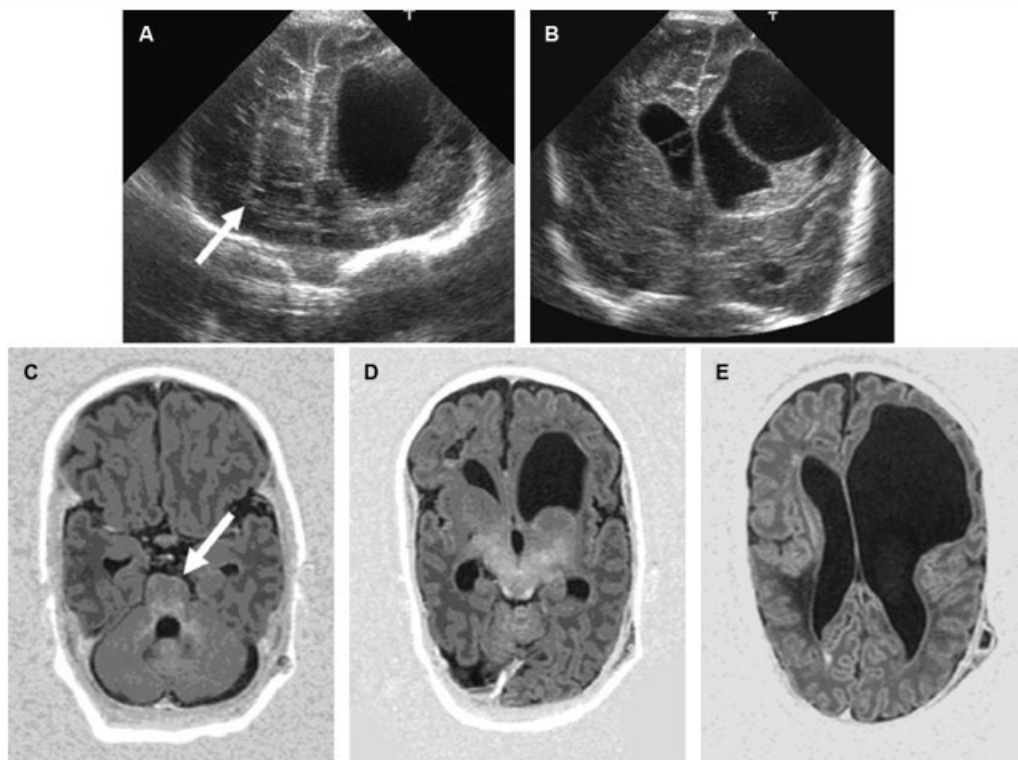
Day 5 cUS (A, B) and term-equivalent age magnetic resonance imaging (C–E) of Patient 1. The coronal ultrasound images show a small cyst in the right frontal periventricular white matter (arrow) (A), and the large left-sided PC (B) with a midline shift to the right and a resolving clot in the left lateral ventricle. The axial inversion recovery sequence images show Wallerian degeneration (arrow) (C), several periventricular cysts in the right frontal periventricular white matter (D), and a porencephalic cyst (E).
